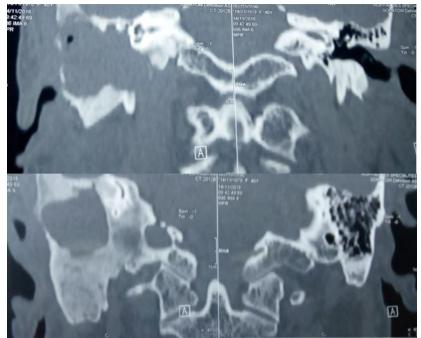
CT-scan: cholesteatoma extended with fibrous dysplasia of the mastoid.
